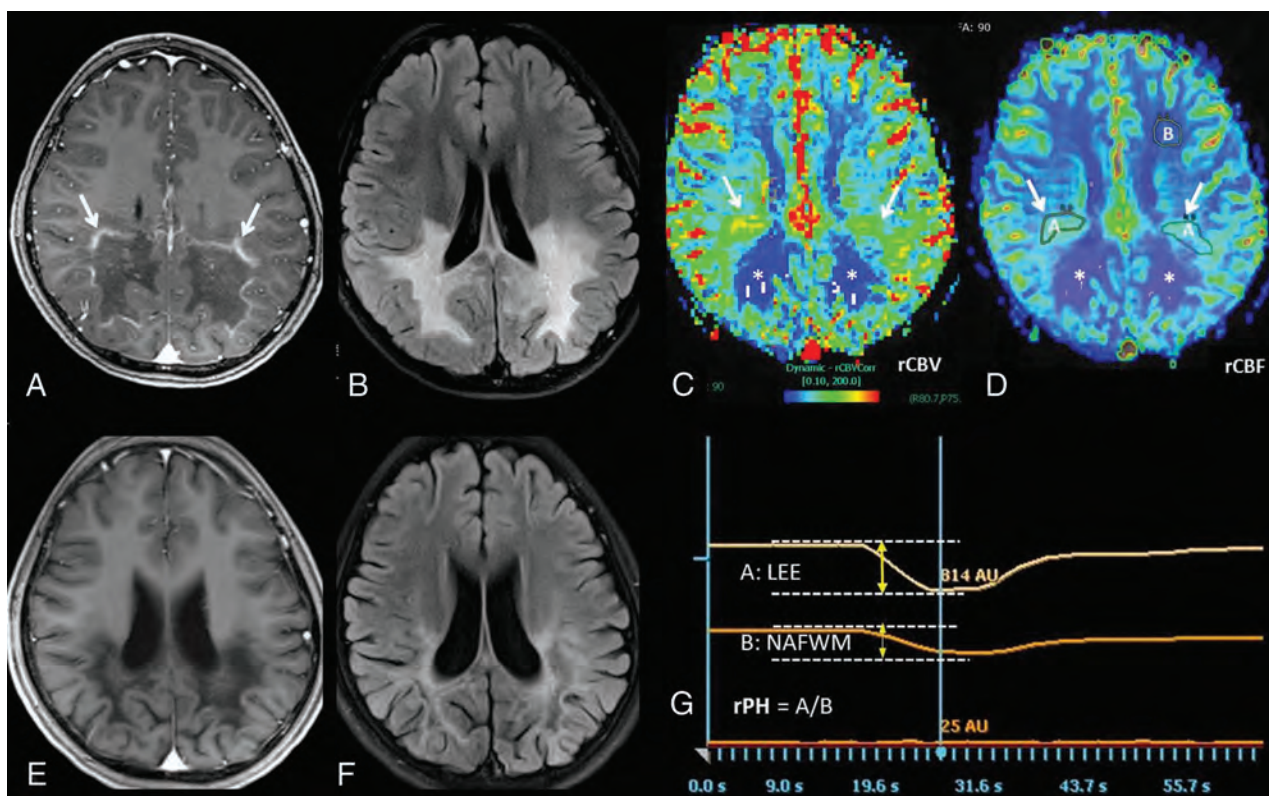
Example of DSC-MRP measurements in a 10-year-old boy with cALD. Baseline (pre-HSCT) MR images show the LEE (arrows) on postcontrast TIWI (A), with typical findings of posterior-type cALD on FLAIR at that time (B). On DSC-MRP at that time, both rCBV (C) and rCBF (D) are mildly elevated at the LEE (arrows) but appear low centrally within the POWM (asterisks). G, The method of relative peak height measurement within the LEE and NAFWM ROIs on the baseline (pre-HSCT) MR imaging examination, via measurement of the dynamic contrast curve. Follow-up MR imaging at 1 year shows that the LEE has resolved on postcontrast TIWI (E) and that the WM abnormalities did not progress on FLAIR (F), though moderate overlying parieto-occipital-predominant atrophy has ensued, with interval sulcal enlargement.
